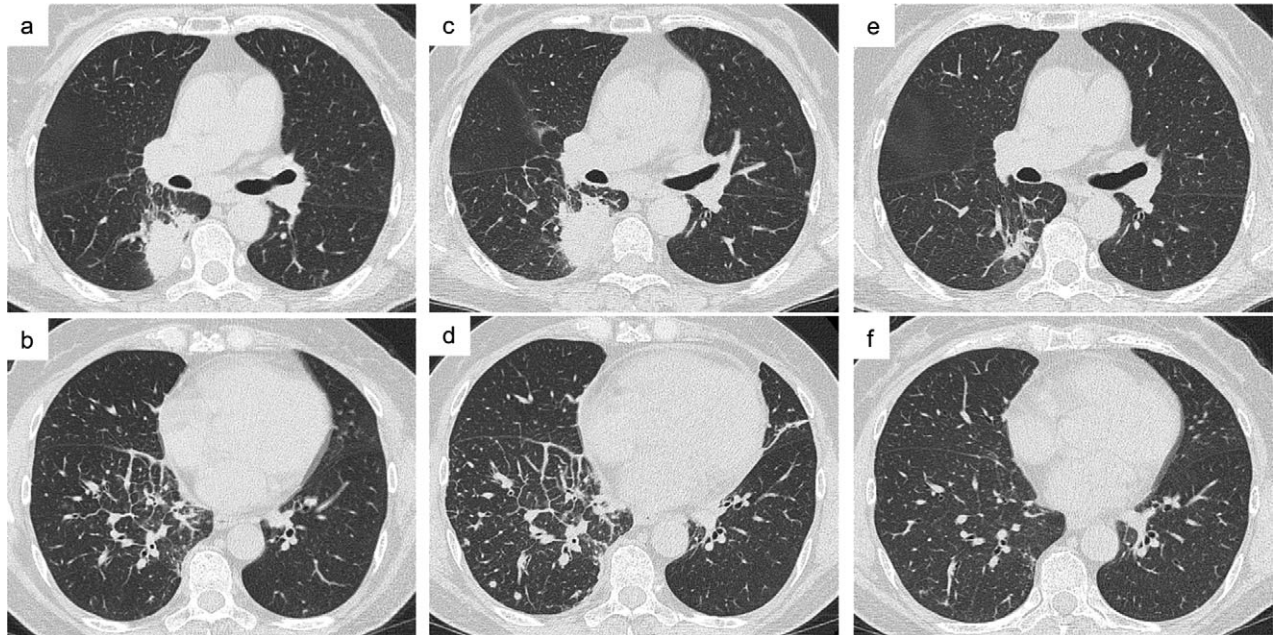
Chest computed tomography scans of the patient with lung adenocarcinoma. Before treatment with afatinib, (a) a 34 mm tumor and (b) interlobular septal thickening were observed in the right lower lobe of the lung. After four weeks of afatinib therapy, and before treatment with osimertinib, (c) the lung tumor had enlarged and (d) new small metastatic nodules had appeared. Six months after treatment with osimertinib, (e) the lung tumor had remarkably regressed, and (f) the metastatic nodules and interlobular septal thickening were no longer observed.
